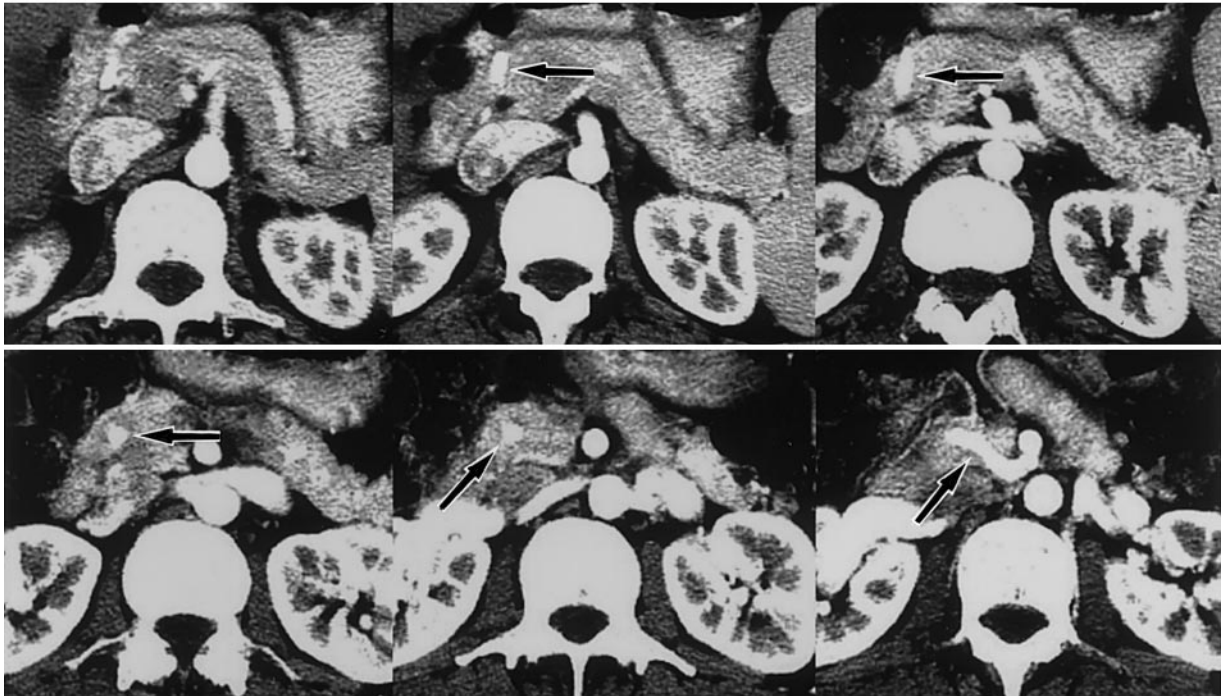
Pancreaticoduodenal arcade with a transpancreatic course. (a) Superior mesenteric arteriogram shows retrograde filling of the celiac branches mainly via a large anterior pancreaticoduodenal arcade. (b) Serial spiral CT scans show the transpancreatic course of the pancreaticoduodenal arcade (arrows), which is buried in the parenchyma of the uncinate process of the pancreas.
